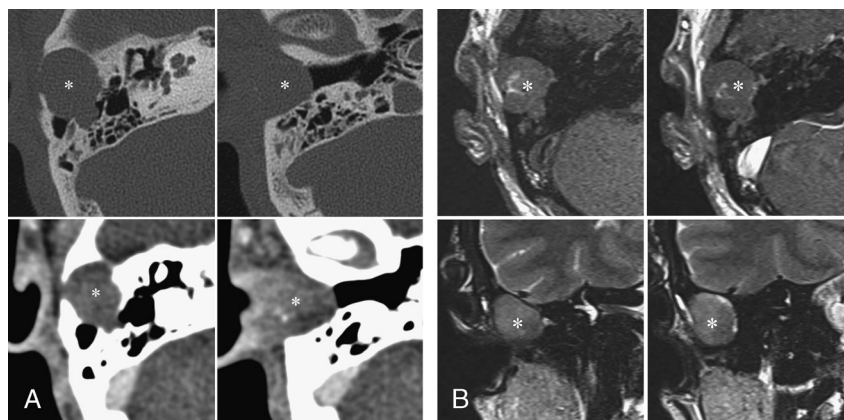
A, Computed tomographic images of right temporal bone before (upper 2 panels) and after contrast enhancement (lower 2 panels). A huge mass of soft tissue density (asterisk) is located at the entrance of EAC and destructed surrounding squama as well as mastoid parts of right temporal bone. B, This mass is isosignal on T1- (left upper panel) and T2-weighted (lower 2 panels) images and not enhanced by gadolinium–diethylenetriamine pentaacetic acid (right upper panel).
